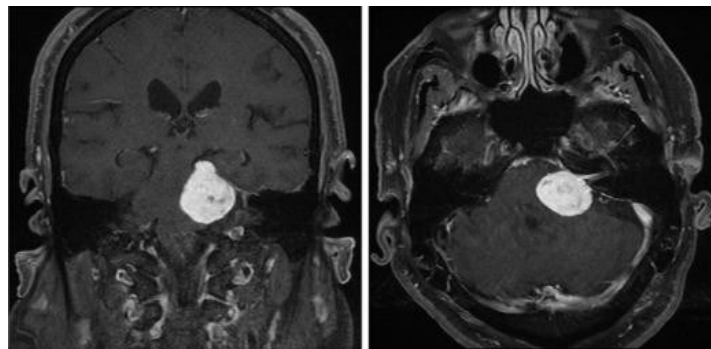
Meningioma with MRI⁸
